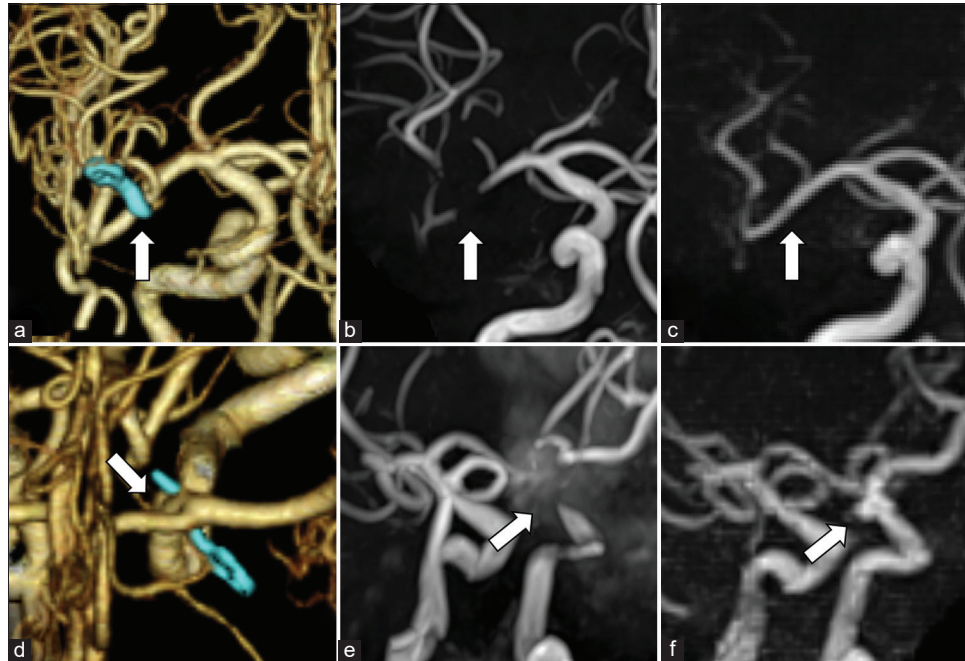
Case 1: clipping for the unruptured aneurysm at the right middle cerebral artery using the Sugita clip made of titanium (Mizuho, Tokyo, Japan). Computed tomography angiography described M1 and M2 portion of the middle cerebral artery and the vicinity of a clip in detail (arrow, a). Time-of-flight magnetic resonance angiography (TOF-MRA) did not describe them due to clip-induced artifact (arrow, b), but pointwise encoding time reduction with radial acquisition (PETRA)-MRA revealed the arteries (arrow, c). Case 2: clipping for the ruptured aneurysm at the left internal carotid artery-posterior communicating artery bifurcation using the Sugita clip made of titanium. CTA described the aneurysm neck remnant due to incomplete clipping (arrow, d), but it was indistinguishable by TOF-MRA (arrow, e). However, PETRA-MRA clearly revealed the remnant and could morphologically evaluate it (arrow, f).
